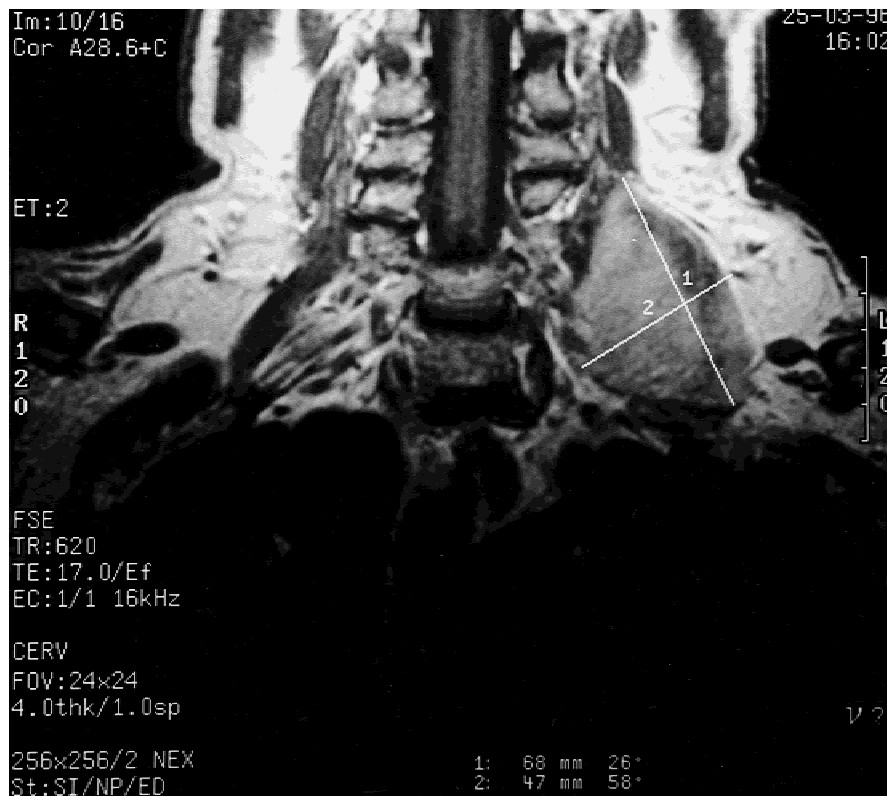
Magnetic resonance imaging of desmoid tumor infiltrating the left cervical region (patient 2).
